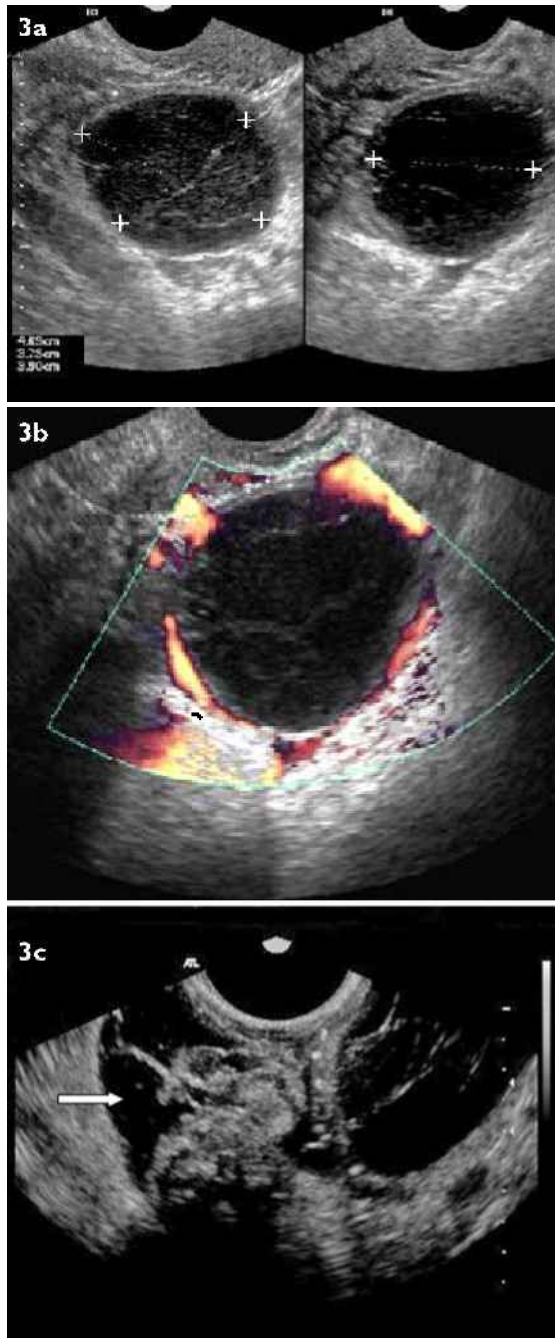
TVUS image of a haemorrhagic corpus luteum shows (a) "spidery" internal reticular strands, low-level internal echoes on grey-scale ultrasonography (US), and (b) a vascular rim on colour Doppler US. (c) Following rupture, the cyst is seen together with varying amounts of adnexal fluid (arrow).
